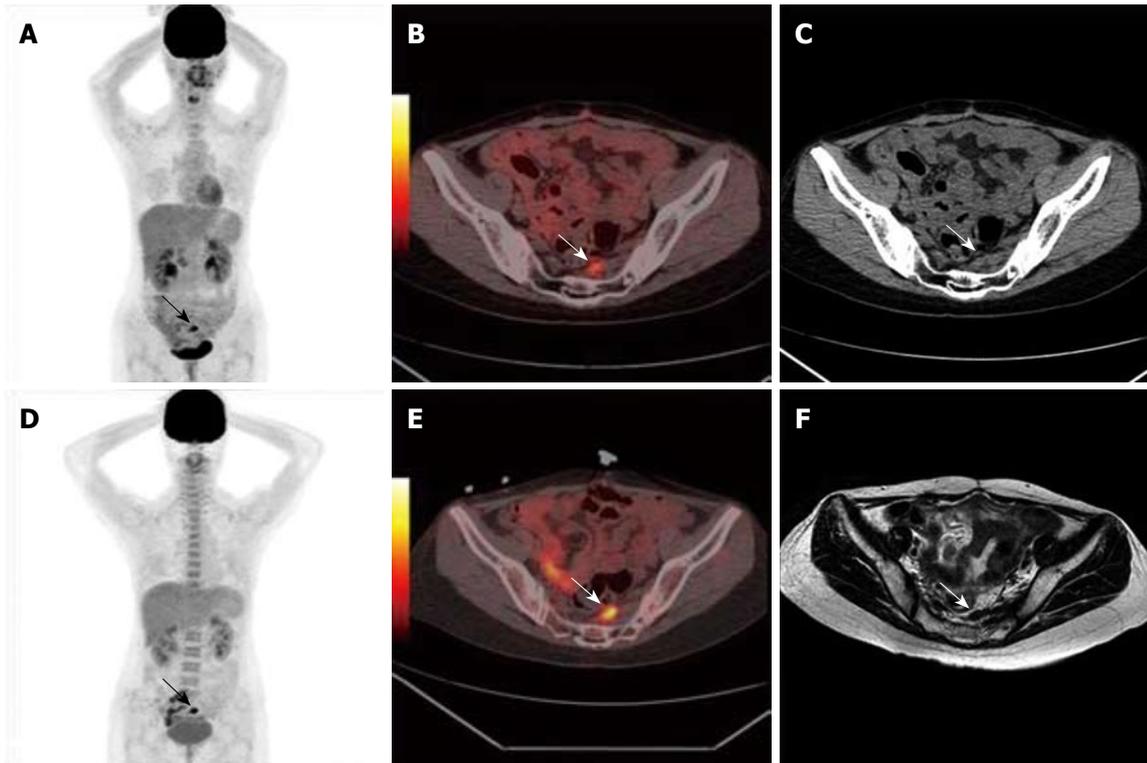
False-positive results. PET/CT obtained in a 34-year-old woman 16 mo after rectal cancer resection. A-C: ^{18}F -FDG uptake in the left side of the pelvis was misinterpreted as tumor recurrence (arrows); D, E: ^{18}F -FDG uptake in the left side of the pelvis was unchanged after 6 mo PET/CT scan (arrows); F: MRI showed no changes of lesion 11 mo follow-up after first PET/CT examination (arrow). The final diagnosis of scar tissue was established by clinical and imaging follow-up.
